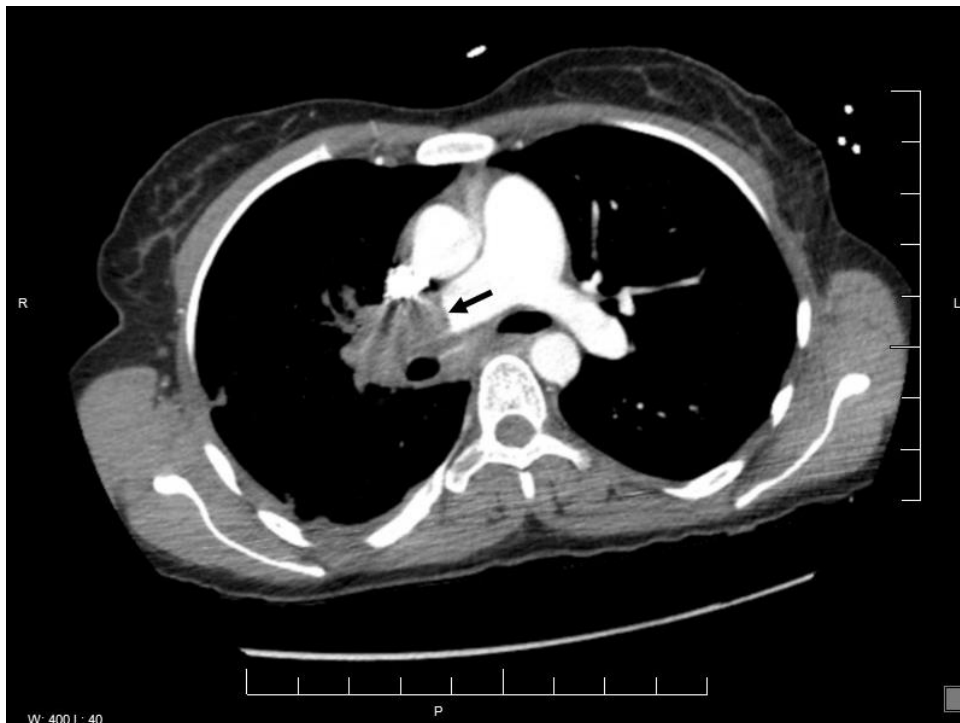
CT pulmonary angiography showing a large pulmonary embolus (arrow) involving the right pulmonary artery. The right pulmonary artery is also dilated (Fleischner sign) compared to the left side.
